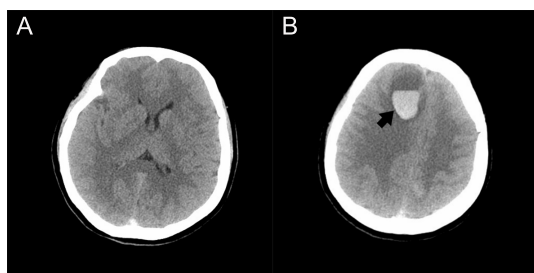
A: The initial CT scan on admission ruled out intracerebral hemorrhage. There is an ambiguous hyperdensity in the superior sagittal sinus. It was difficult to diagnose CVT at that moment based on this atypical, B: A CT scan at 2 hours after rtPA thrombolysis revealed a right frontal lobe hematoma (arrow). The middle line was left-shifted, with progressed paralysis and decreased consciousness level CT: computed tomography; sign CT: computed tomography; CVT: cerebral venous thrombosis; rtPA: recombinant tissue plasminogen activator
